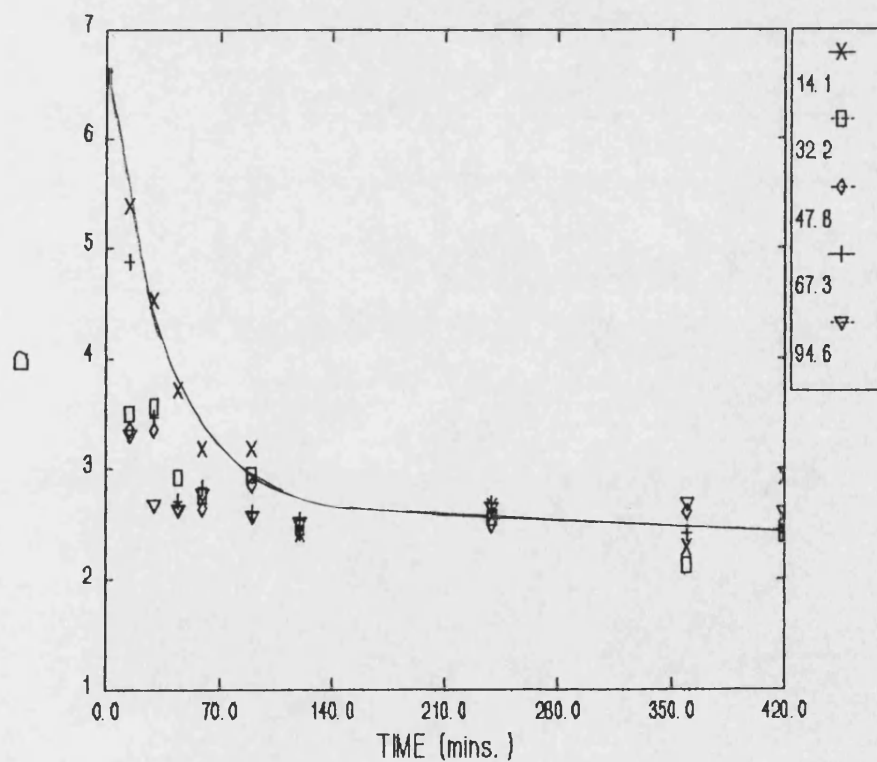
The effect of sonication at various ultrasonic intensities upon the molecular weight distribution.
